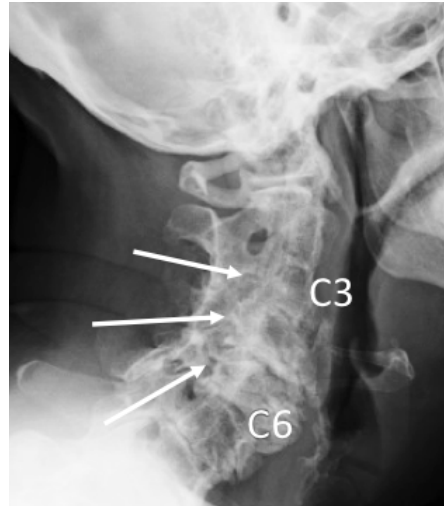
Pre-operative anteroposterior cervical spine x-ray showing cervical scoliosis, extensive cervical stenosis at C3-6, and loss of intervertebral disc space (arrows).
